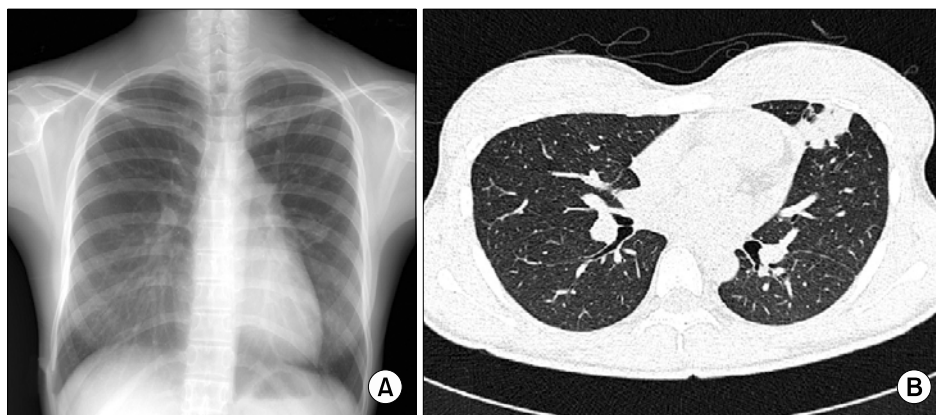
(A) 6 months after anti-TB medication, The chest radiography reveals aggravation of multiple nodules at left upper lobe. (B) High resolution computed tomography shows newly developed consolidation at left upper lobe.
